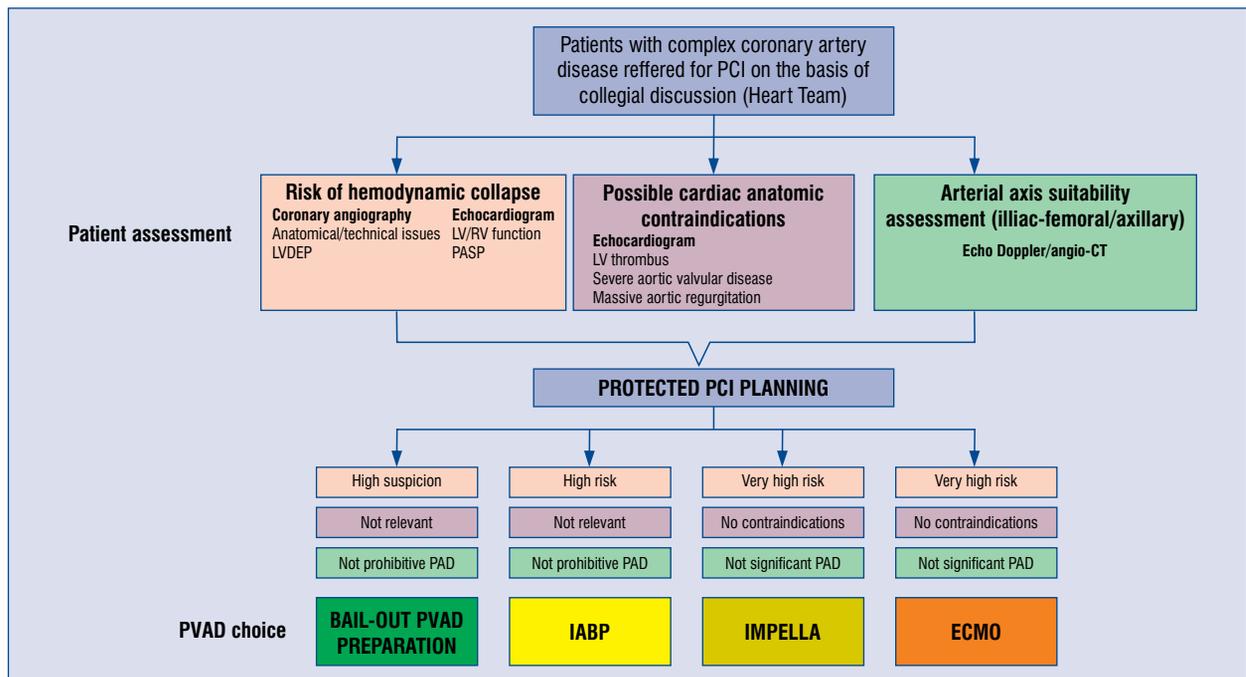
Proposed pre-procedural assessment and percutaneous ventricular assistance device (PVAD) choice in the context of high-risk percutaneous coronary intervention (PCI); LVEDP — left ventricle end-diastolic pressure; PASP — pulmonary artery systolic pressure; PAD — peripheral artery disease; CT — computed tomography; IABP — intra-aortic-balloon pump; LV — left ventricle; RV — right ventricle; ECMO — extracorporeal membrane oxygenation.
